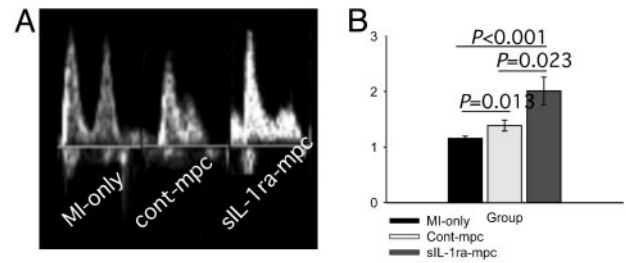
LV diastolic function in infarcted hearts at 3 weeks. Diastolic trans-mitral E/A ratios were determined by measuring the height of peaks of flow through the mitral valve; representative echocardiographic spectral Doppler images are shown (A) SkM implantation had a significant beneficial effect on E/A ratio compared with nonengrafted infarcted hearts; this effect was greatest with sIL-1ra-SkM (B). All values mean \pm SEM; $n = 5$ for each group.
